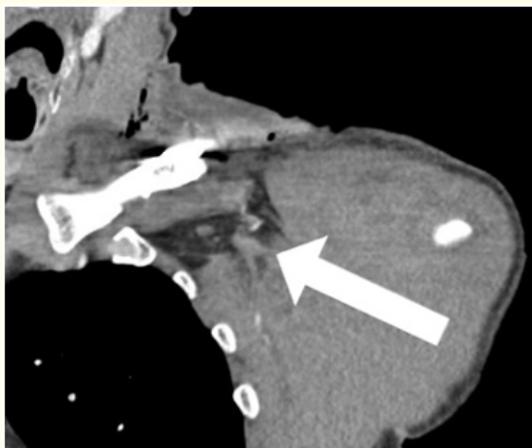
Axial view of CT angiography of the left upper chest and proximal left upper extremity revealing diffuse enlargement and increased signal intensity of the subclavius muscle, presumably related to intramuscular hemorrhage (white arrow).
